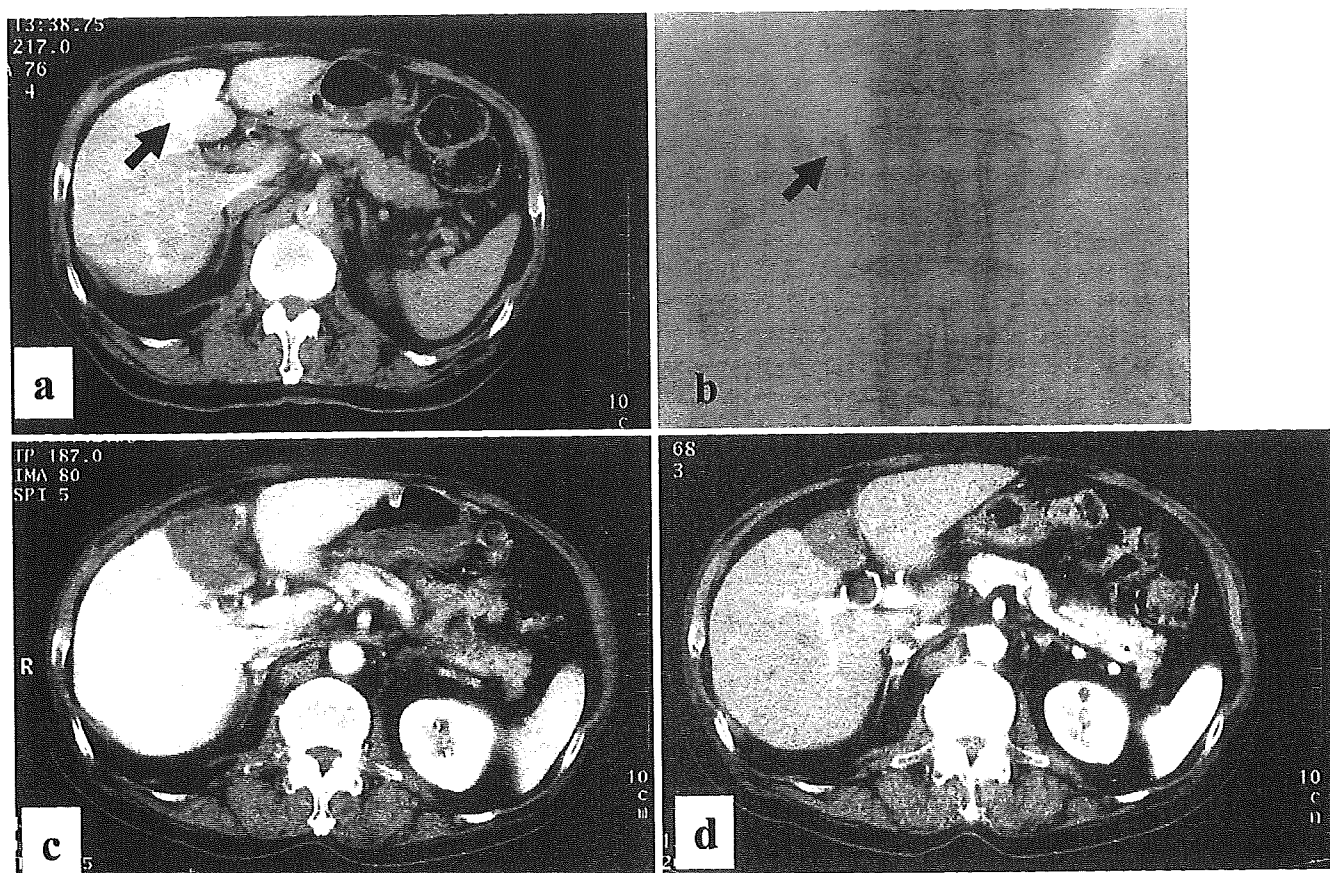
Balloon-microcatheter-occluded RFA, using a cool RF single electrode, in a 68-year-old man with a 28-mm-diameter hepatocellular carcinoma in segment 4. a CTA before treatment shows a tumor (*arrow*). b The balloon microcatheter (*arrow*) is placed in the left hepatic artery. We performed balloon-microcatheter-occluded RFA, using a cool RF single electrode (number of needle insertions, 1; treatment time, 12 min). c Dynamic CT scan taken 1 week after treatment shows no enhancement in the treated area (43 × 40 mm). d Dynamic CT scan taken 1 year after treatment shows no enhancement in the treated area
